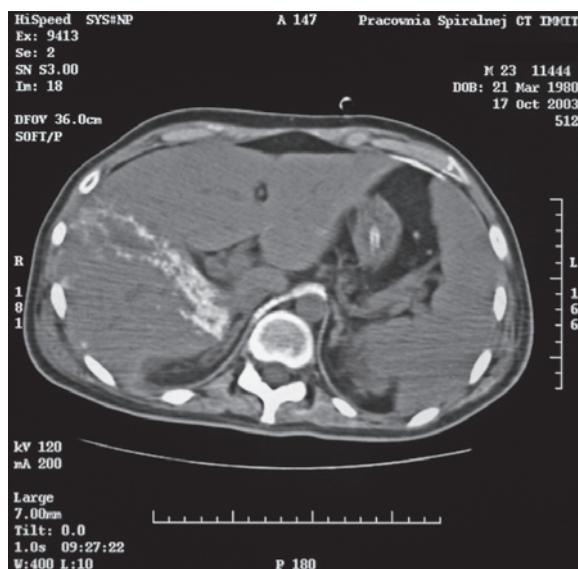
CT performed 3 weeks after the accident demonstrated diffuse hepatic calcification. Calcified right diaphragm crus is also revealed.
